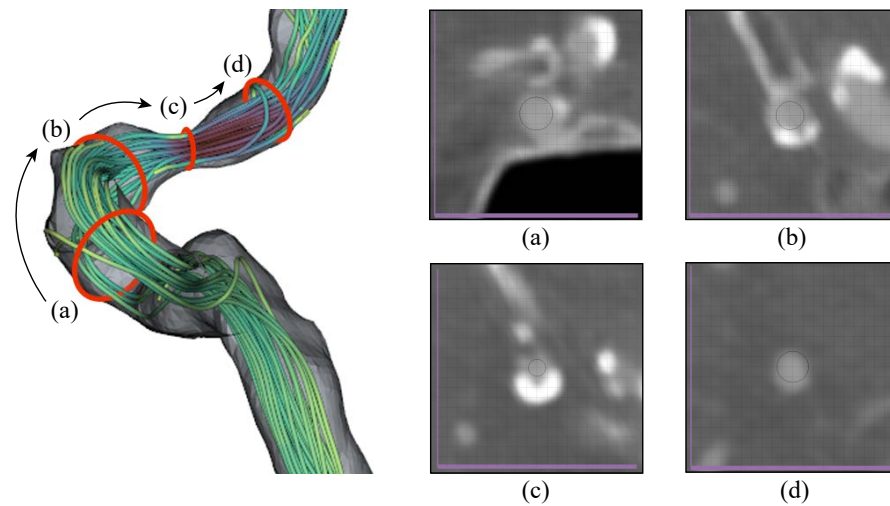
The probe follows the vessel's direction when dragged. This gives an accurate depiction of the lumen diameter, which is essential when assessing the stenosis at (c). Probing the CTA volume unveils the cause of this stenosis – a buildup of plaque on the vessel wall.
